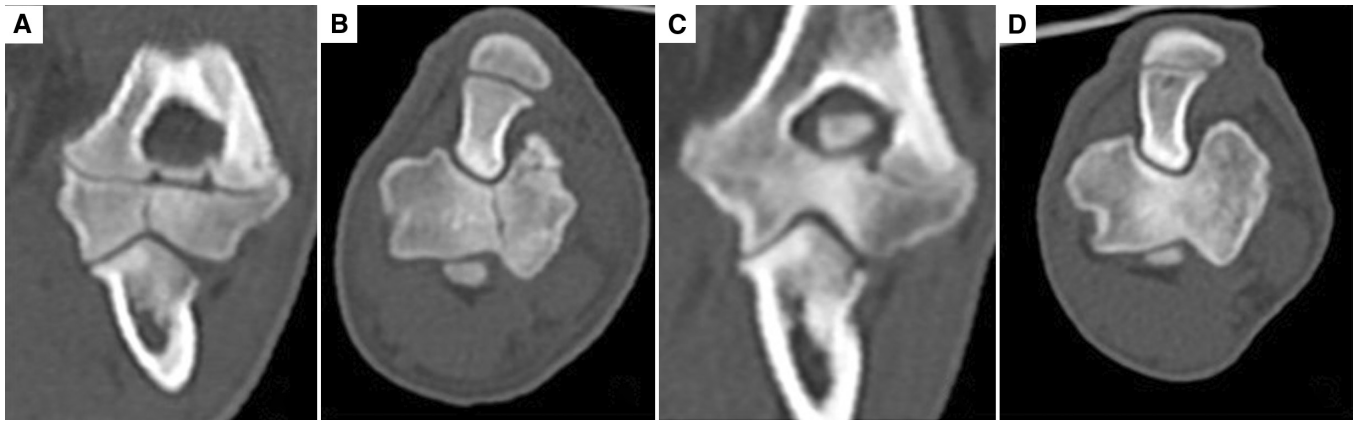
Dorsal (A) and transverse (B) computed tomography reconstructions of an elbow in a 4-month-old French bulldog. There is a hypoattenuating line extending across the entire length of the humeral condyle, surrounded by hyperattenuating, sclerotic bone. Computed tomography reconstructions 5 weeks later, revealed fusion of the fissure in dorsal (C) and transverse (D) planes. The hypoattenuating line has been replaced with hyperattenuating, sclerotic bone.
